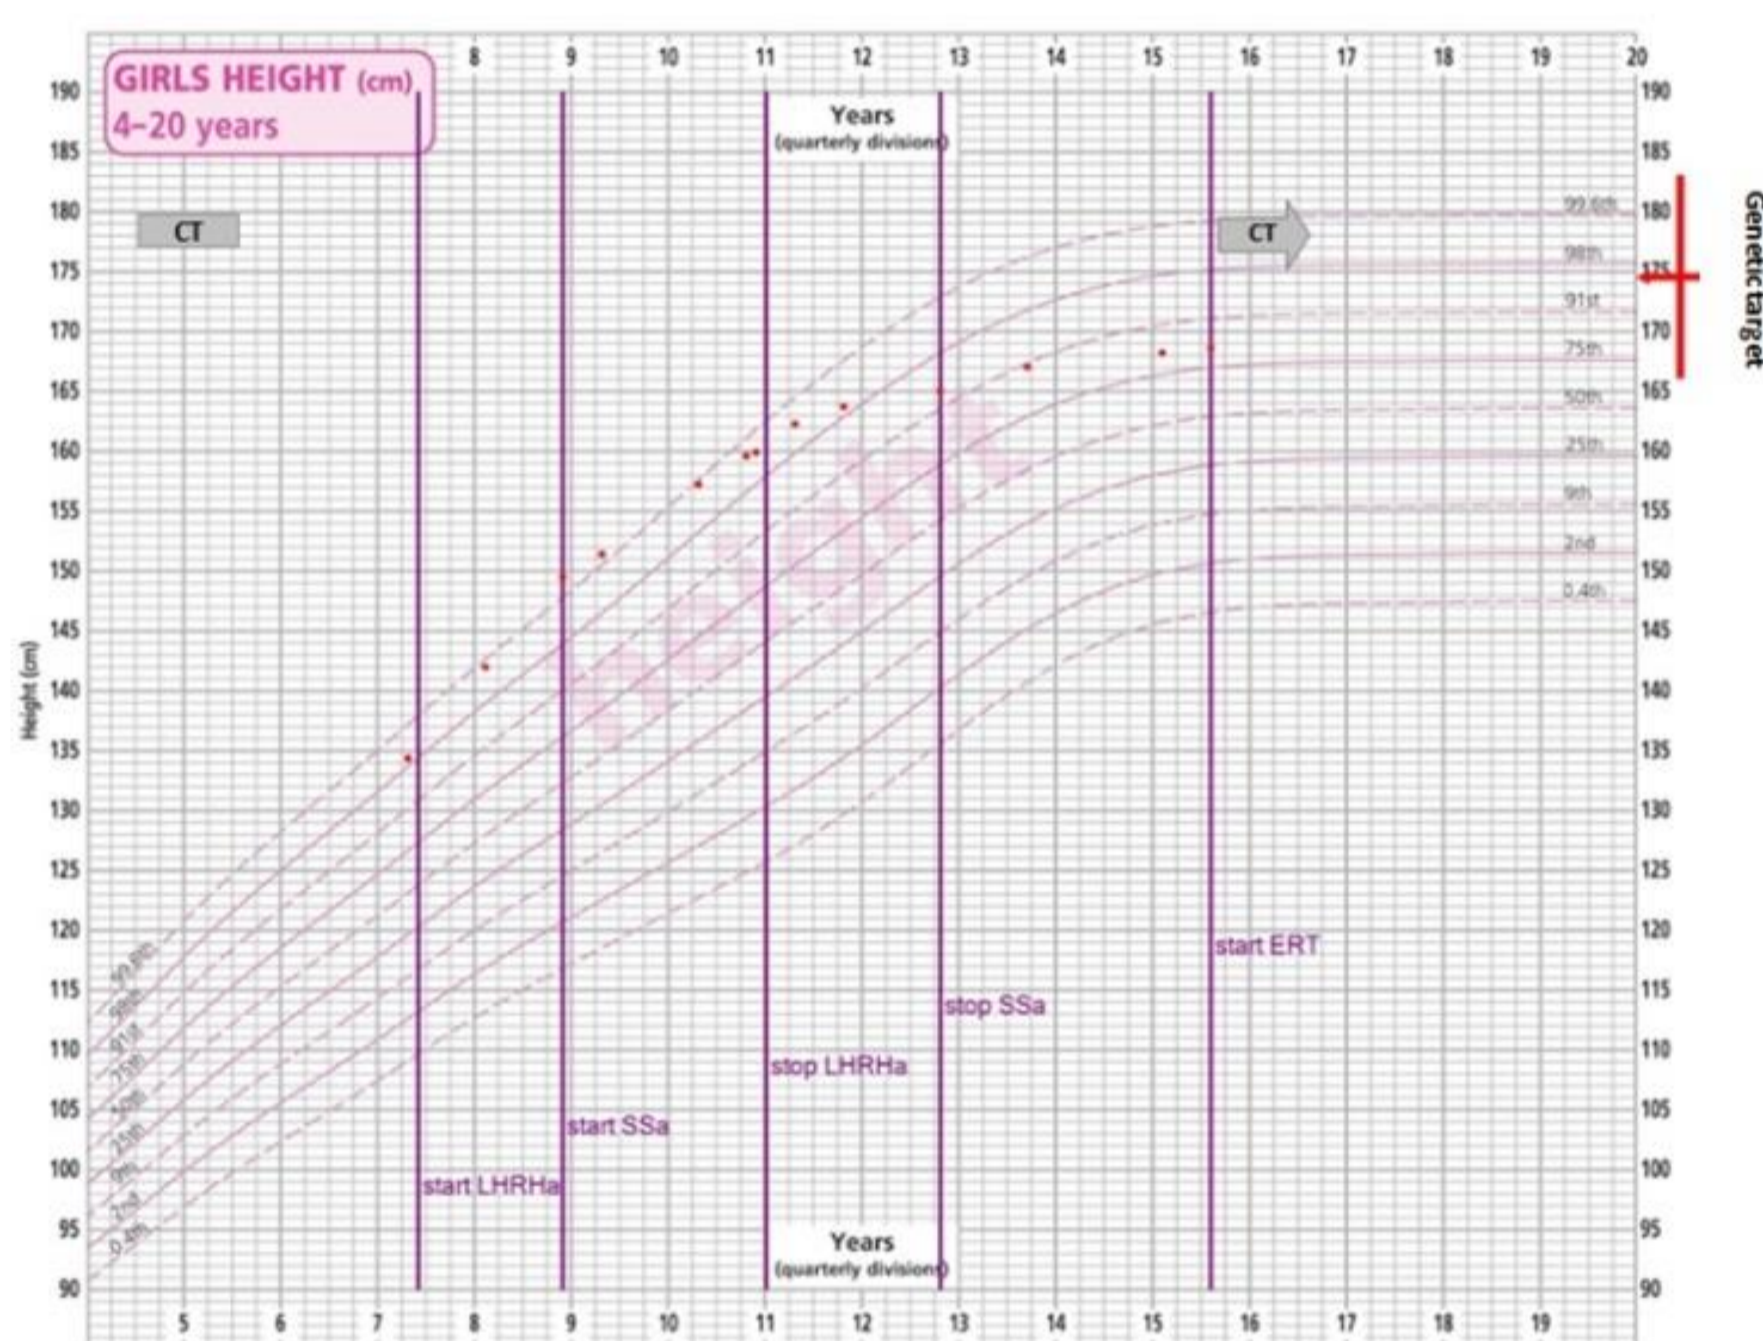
Case 2: Height chart and timing of chemotherapy (CT, horizontal bars), SSa, LHRHa and ERT treatments (vertical lines). The arrow bar represents an ongoing CT on last follow up.
